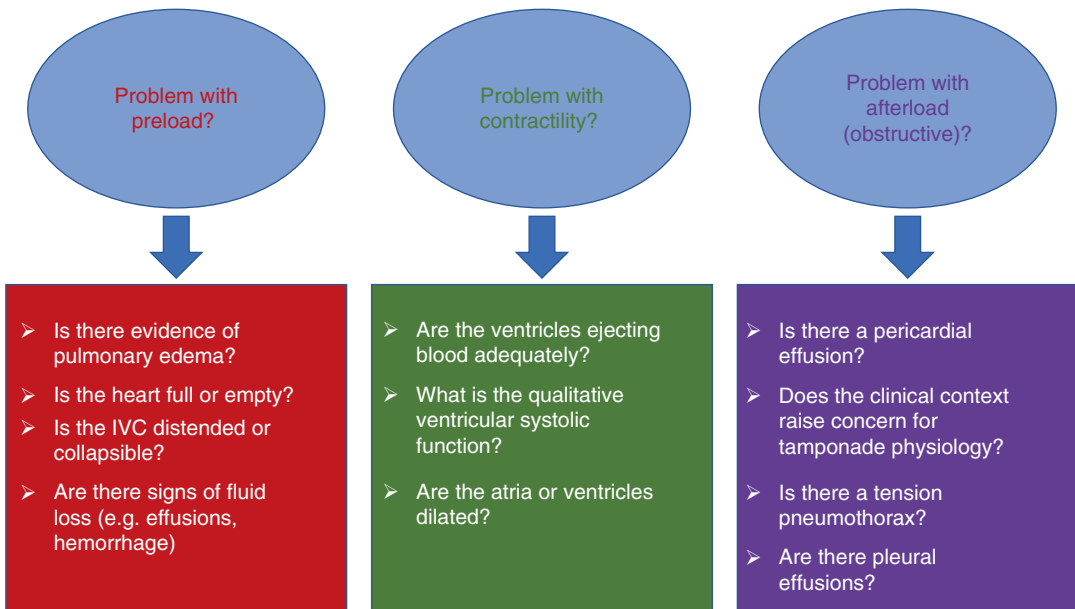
Clinical questions regarding shock states that can be answered using point of care ultrasound
